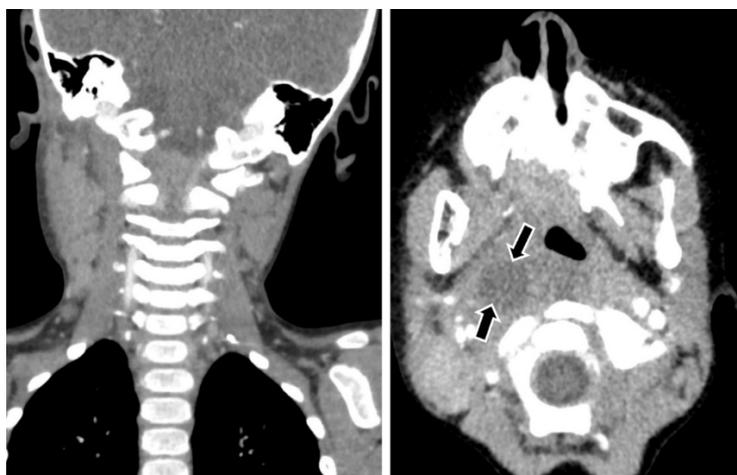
Retropharyngeal abscess and associated torticollis; contrast-enhanced neck CT demonstrates a right-sided retropharyngeal abscess (arrows).
